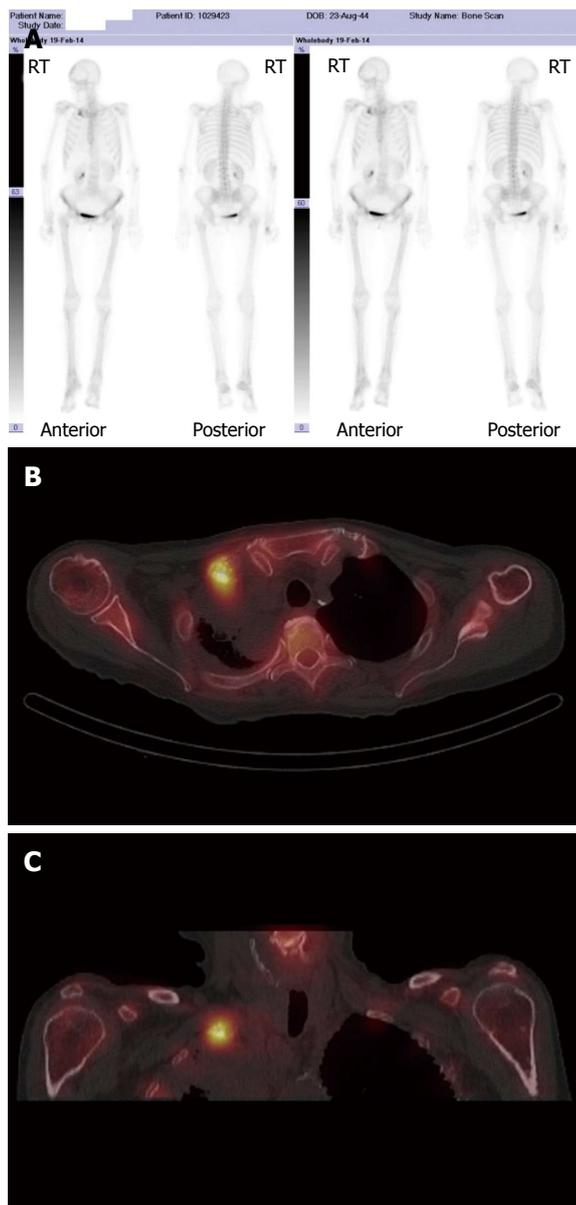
Single photon emission computed tomography has higher sensitivity and specificity for detection of bone metastasis when compared with bone scintigraphy. A: Abnormal accumulation of radiotracer in the right clavicle on bone scintigraphy in a patient with primary lung malignancy; Axial (B) and coronal (C) single photon emission CT/CT images demonstrate the superior spatial and contrast resolution of this hybrid technique which enables improved detection and characterisation on bone metastases.
